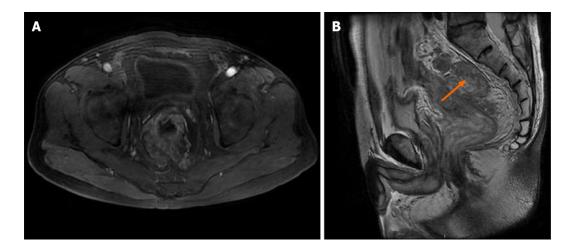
Preoperative magnetic resonance imaging scans. A: Magnetic resonance imaging (MRI) showed a lesion breaking through the adventitia horizontally; B: MRI showed the lesion located in the upper rectum and the neoplasm breaking through the rectal adventitia (orange arrow).
